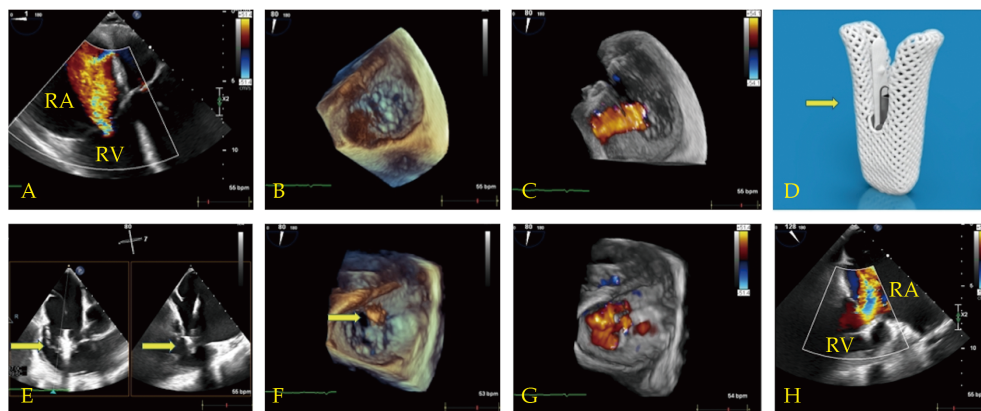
TEE guided tri-clip implantation. (A): 2DTEE demonstrating severe tricuspid regurgitation; (B): 3DTEE demonstrating tricuspid valve; (C): 3DTEE with color doppler imaging demonstrating severe tricuspid regurgitation; (D): Abbott TriClip; (E): 2DTEE with bi-plane mode demonstrating TriClip across the tricuspid valve; (F): 3DTEE demonstrating TriClip post-deployment; and (G): 3DTEE with color doppler imaging demonstrating improvement in tricuspid regurgitation post TriClip deployment; (H): 2DTEE improvement in tricuspid regurgitation post TriClip deployment. Arrow: TriClip; RA: right atrium; RV: right ventricle; 2DTEE: two-dimensional transesophageal echocardiogram.
